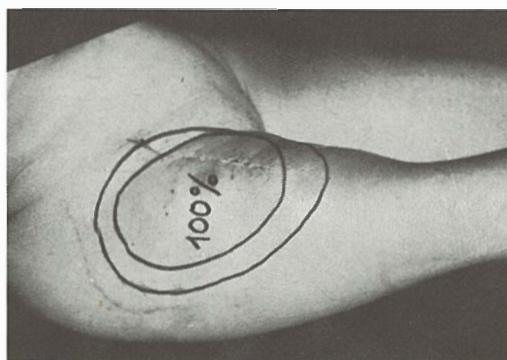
Patient No. 1, soft tissue metastasis of an anaplastic clear cell carcinoma (12 × 16 cm) before CT (outer circle), after test dose of VLB 2 mg/24<sup>h</sup> and CDP 70 mg/12<sup>h</sup> (inner circle). A CR was achieved after the first course of CT with VLB 2 mg, CDP 70 mg, MTX 50 mg, Bleo 15 mg and 5-Fu 500 mg.
